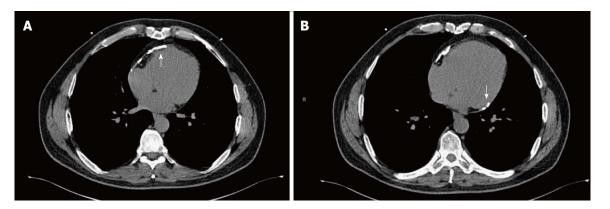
Non-contrast cardiac computed tomography for coronary artery calcium scoring showed moderate pericardial calcification mostly involving anterior (A) and inferobasal (B) portion of the pericardium.
